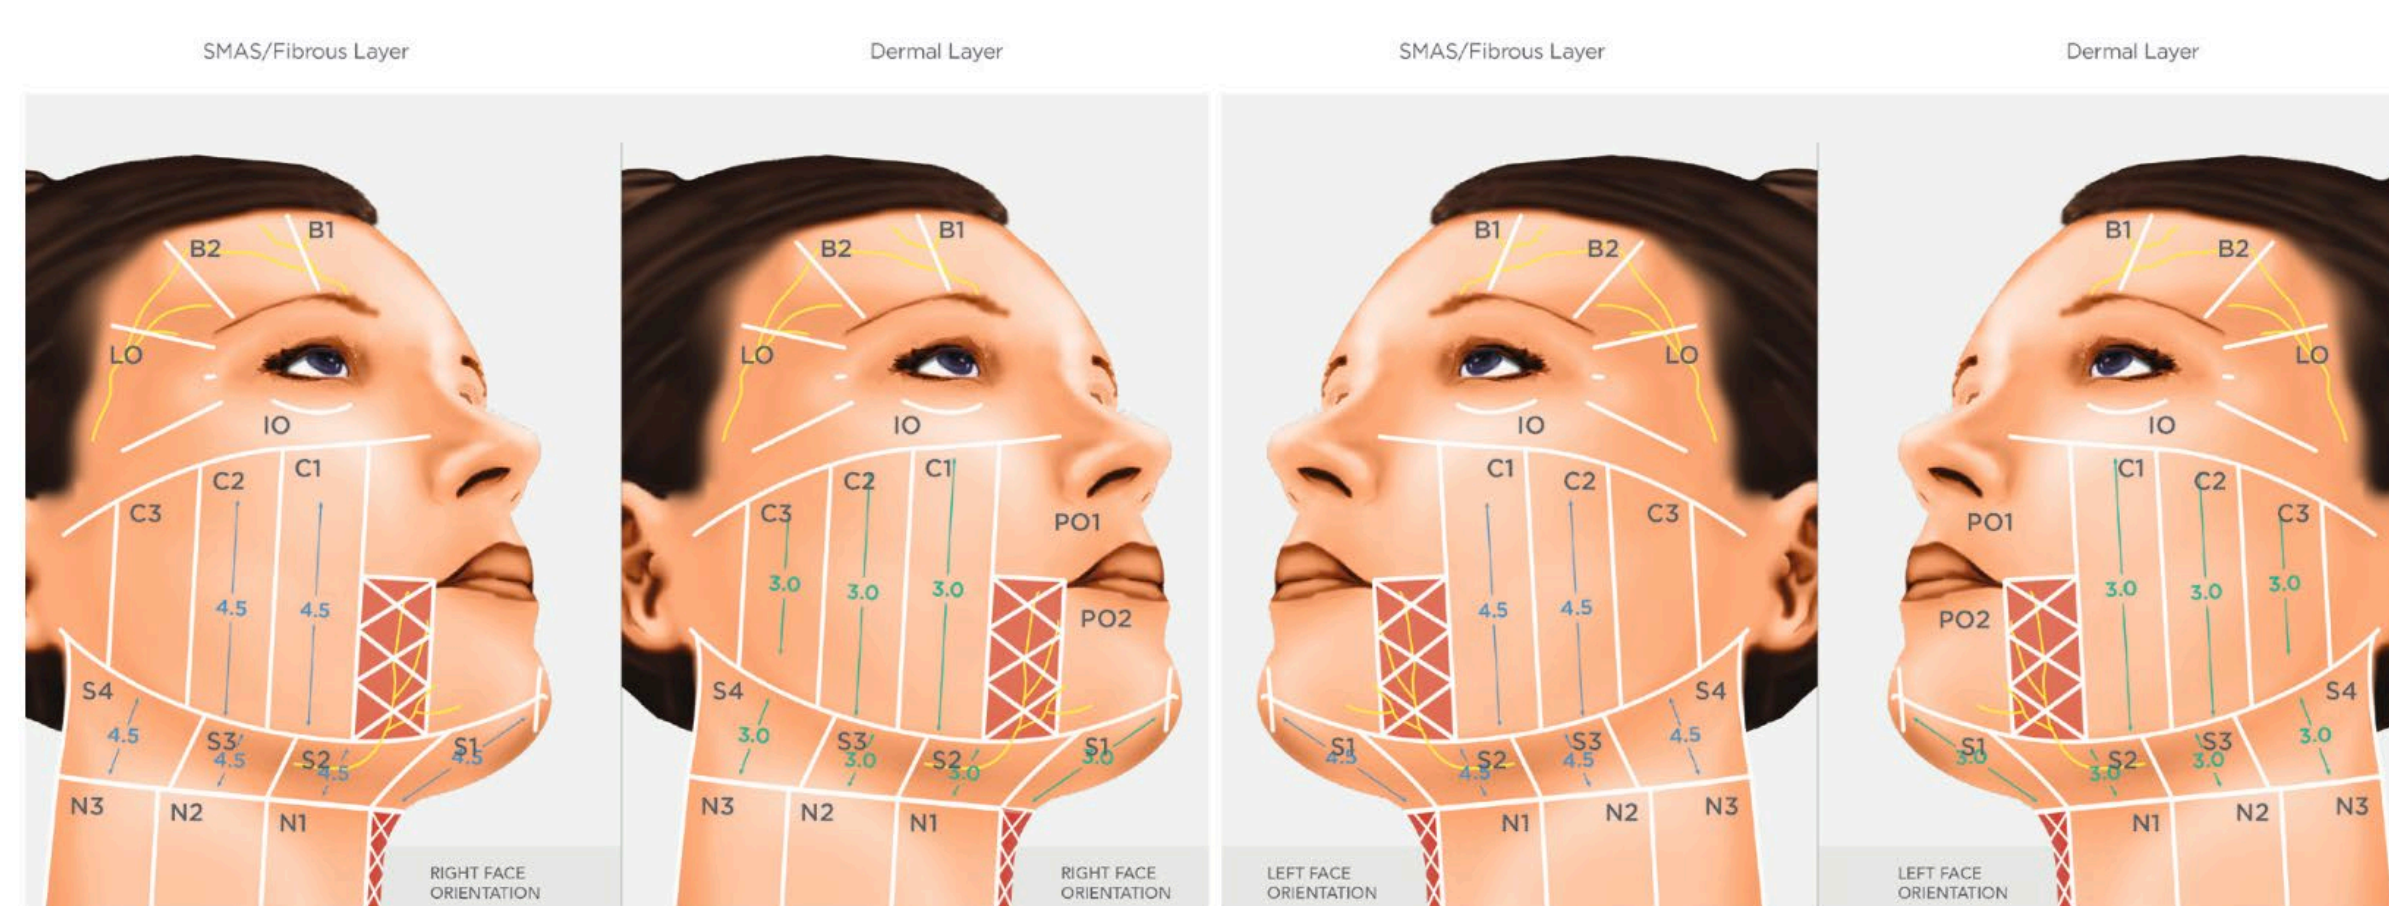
Micro-focused ultrasound Patient Planning Record for this case (Merz)
